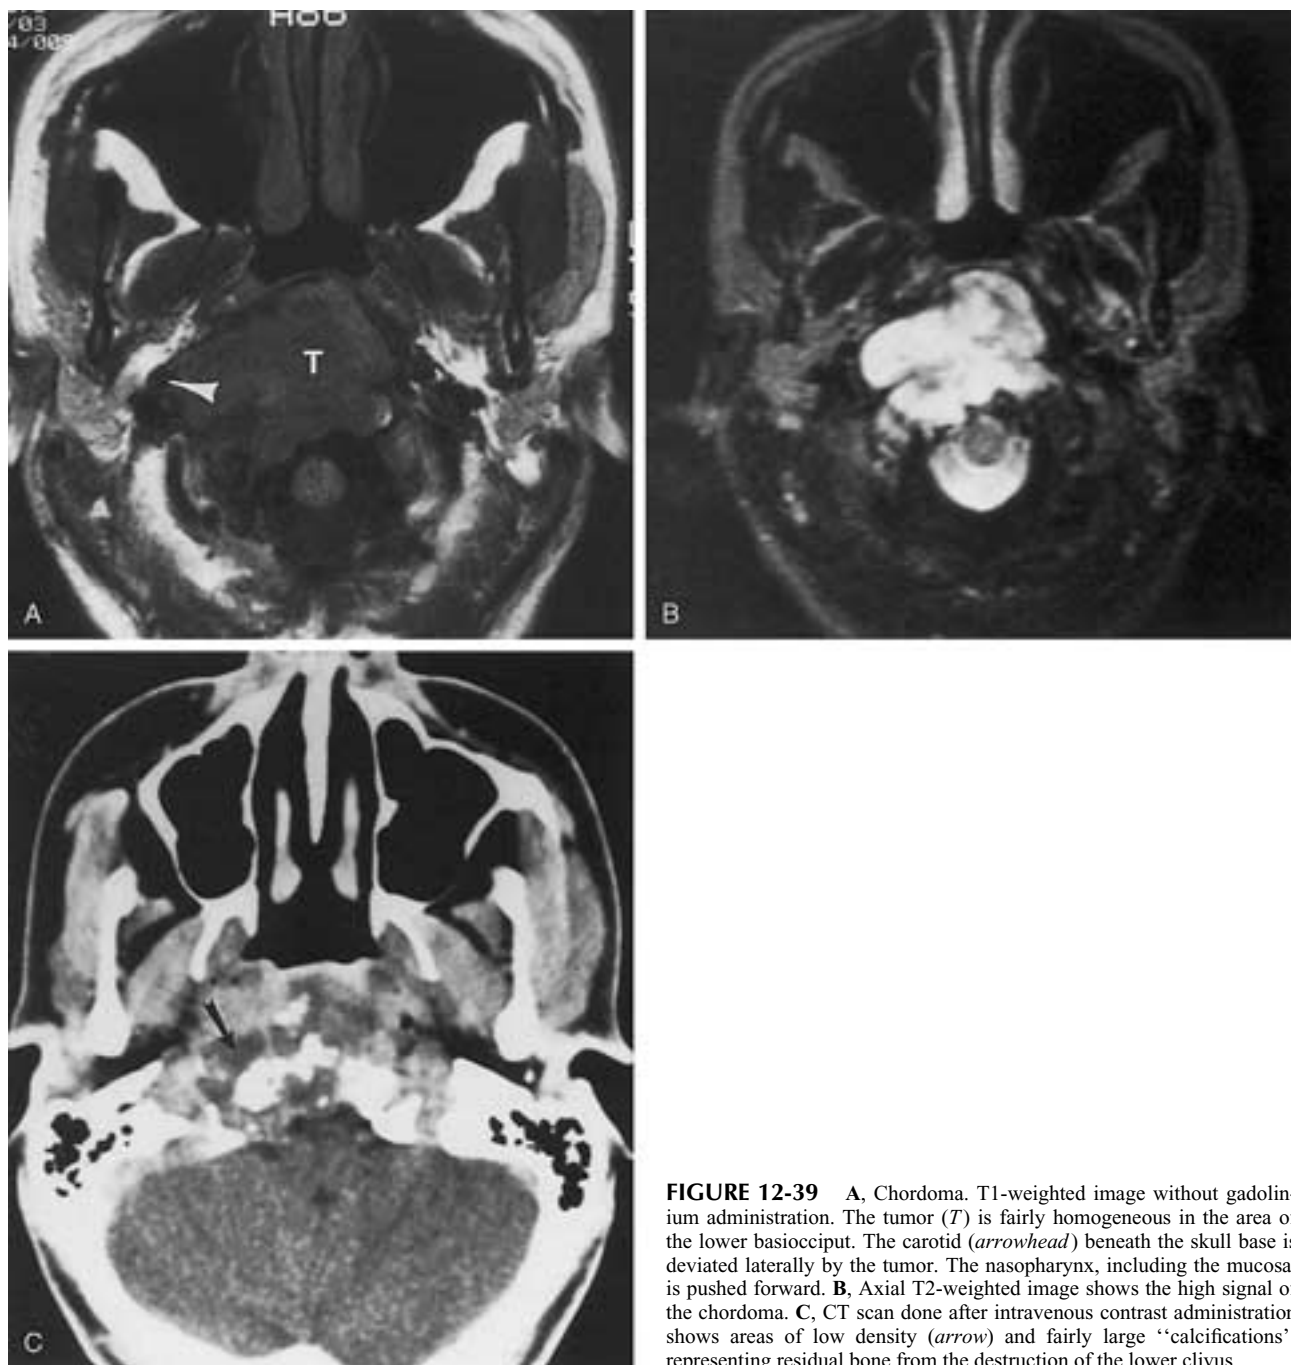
A, Chordoma. T1-weighted image without gadolinium administration. The tumor (*T*) is fairly homogeneous in the area of the lower basiocciput. The carotid (*arrowhead*) beneath the skull base is deviated laterally by the tumor. The nasopharynx, including the mucosa, is pushed forward. B, Axial T2-weighted image shows the high signal of the chordoma. C, CT scan done after intravenous contrast administration shows areas of low density (*arrow*) and fairly large “calcifications” representing residual bone from the destruction of the lower clivus.
